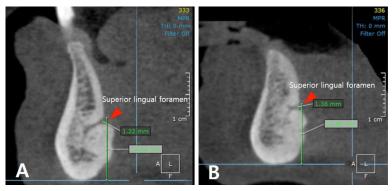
CBCT images of the superior lingual foramina with a diameter of ≥1 mm (arrowheads) in elderly Korean. A, Dentulous patient. B, Edentulous patient.
